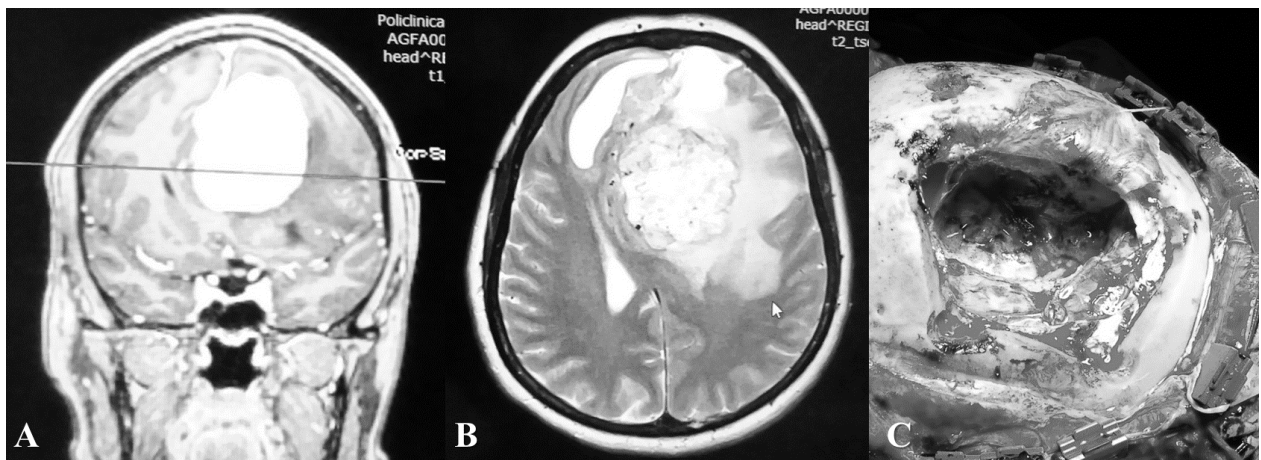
Preoperative coronal (A) and axial (B) T1-weighted images with contrast showing a left falcine meningioma. Postoperative images showing tumour bed after gross total resection (C) (Assoc. Professor Turliuc's personal collection)
